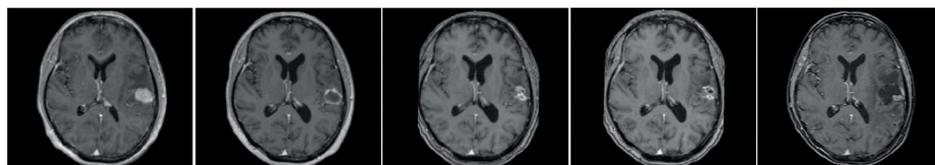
Five consecutive co-registered MRI scans of patient 7, from left to right before SRT, after 3 months, 1, 2 and 4 years. Development of a cystic lesion, compatible with late radiation necrosis of brain tissue. Especially in the first two years it is difficult to separate changes in tumor and brain tissue based on static images.
